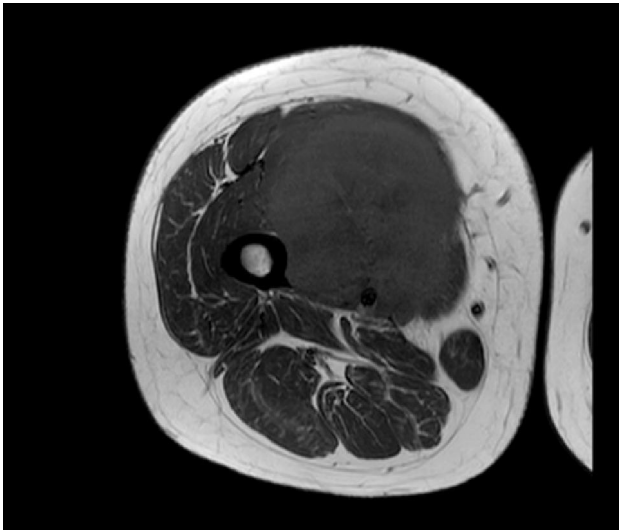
MRI axial T1WI showing large mass involving the vastus medialis muscle in anteromedial aspect of right thigh; Note the tumor is completely encasing the adjacent femoral vessels and nerve and is closely applied to medial surface of femur with intact cortex.
